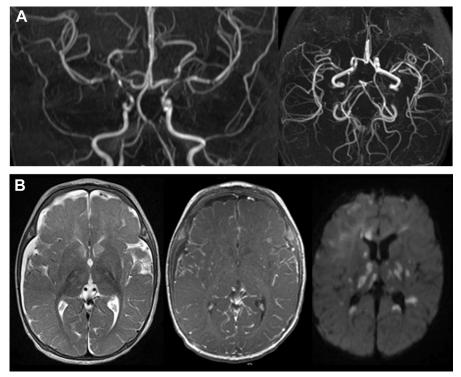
(*A*) Coronal and axial MRA in a case of CNS vasculitis. A significant narrowing and irregularity is noted, affecting the distal internal carotid arteries bilaterally as well as the M1 and M2-segments of both middle cerebral arteries. (*B*) Axial T2 images show multifocal, ill-defined T2-hyperintense lesions within the central gray matter, hemispheric white matter, and cortical gray matter bilaterally. Most of the T2-hyperintense lesions are more conspicuous on diffusion-weighted imaging (DWI) and reveal imaging characteristics compatible with cytotoxic edema (DWI-hyperintense). On the contrast-enhanced sequence, mild diffuse leptomeningeal enhancement is noted as well as an increased vessel enhancement.
